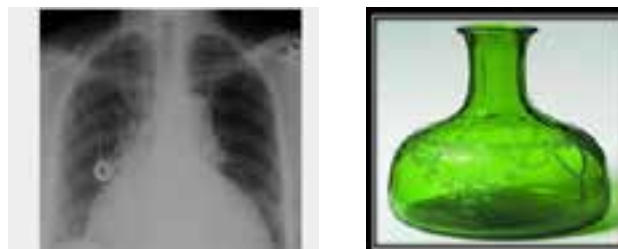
Water bottle sign. Frontal chest radiograph demonstrates a large pericardial effusion. The globular shape of the heart resembles a water bottle.
